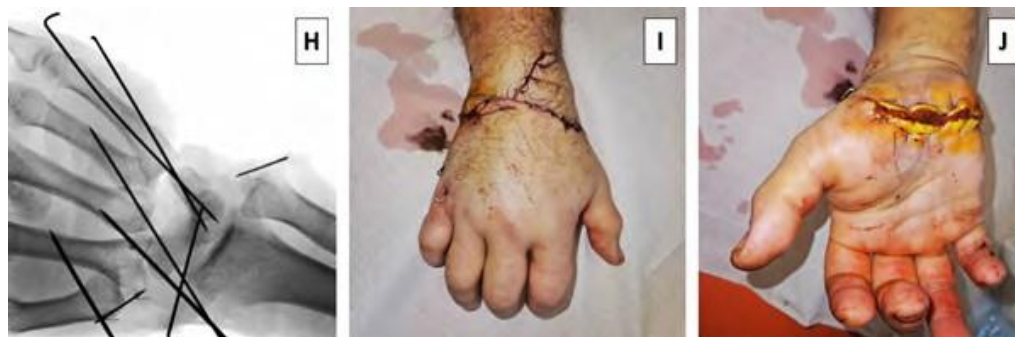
(H) Intraoperative radiograph demonstrates the implementation of Kirschner wires for securing MKK (I, II, III, IV, V) to the bones of the proximal carpal row. (I, J) Postoperative images reveal the right arm of the patient following surgery, just before the cast is applied for immobilization.
